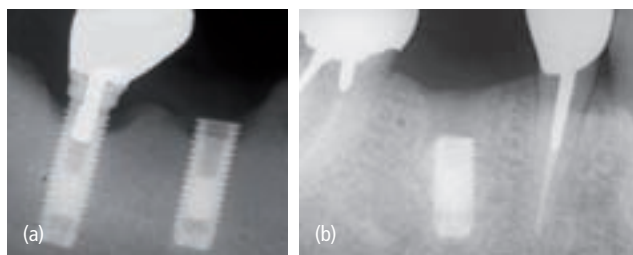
(a) The mandibular implant fractured owing to heavy occlusal forces. (b) Periapical radiograph of the fractured implant. The fracture occurred about 3 months after cementation of the crown.
